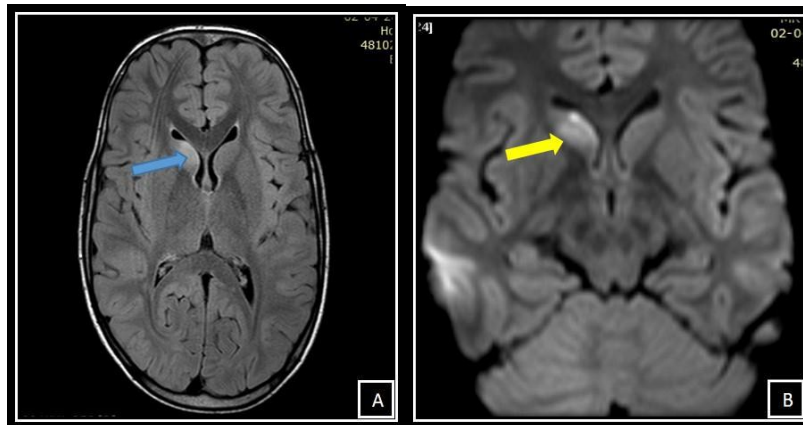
Cerebral Malaria: A: FLAIR, B: DWI.
